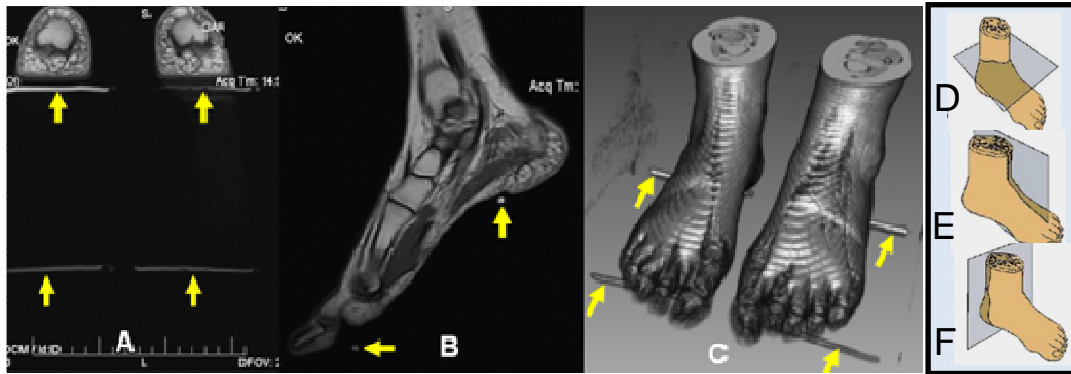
MRI of the Feet of a Healthy Volunteer. The External Markers are Identified Using Arrows. (A) Coronal Slice; (B) Sagittal Slice; (C) 3D Reconstruction. D-F Show the Coronal (D) Sagittal (E) and Axial (F) Selected Orientations.
